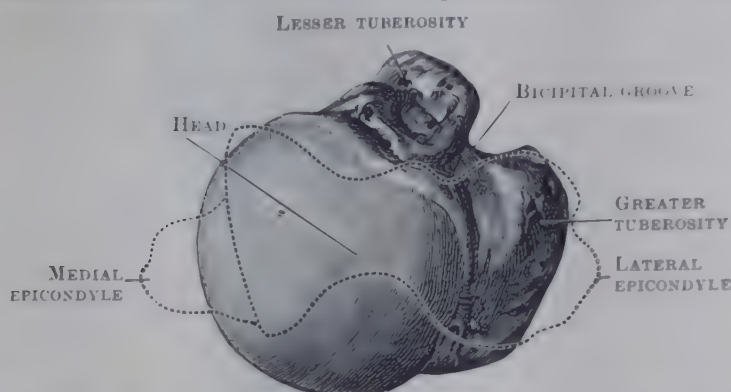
PROXIMAL ASPECT OF RIGHT HUMERUS (with the outline of lower end in relation to it in dotted line).
